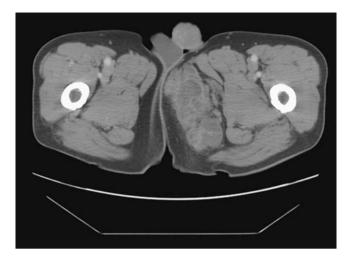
Contrast-enhanced CT image of a peroneal/upper thigh extraskeletal myxoid chondrosarcoma
